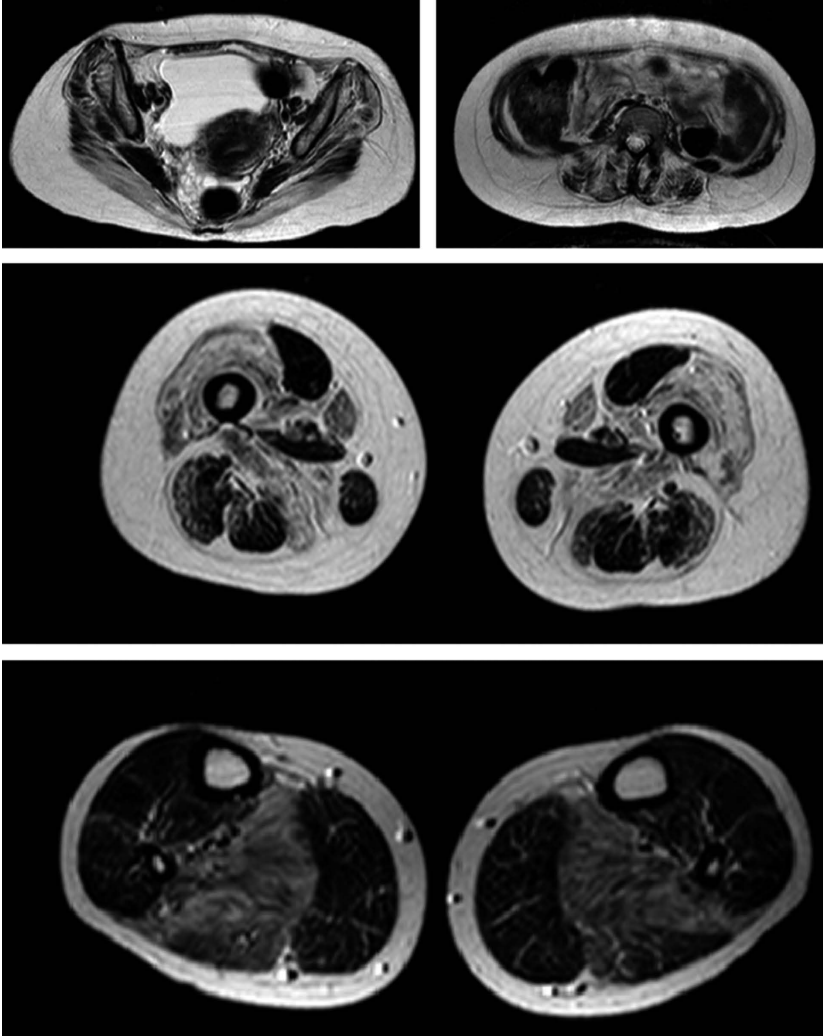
Muscle MRI images. Typical pattern of selective muscle involvement detected in a DMD boy using T1 weighted muscle MRI images. In the upper panel (pelvis) there is severe involvement of the glutei; in the intermediate panel (thighs) there is severe involvement of the vasti and off the adductor magnus, while at the calf level (lower panel), there is moderate involvement of the soleus.
